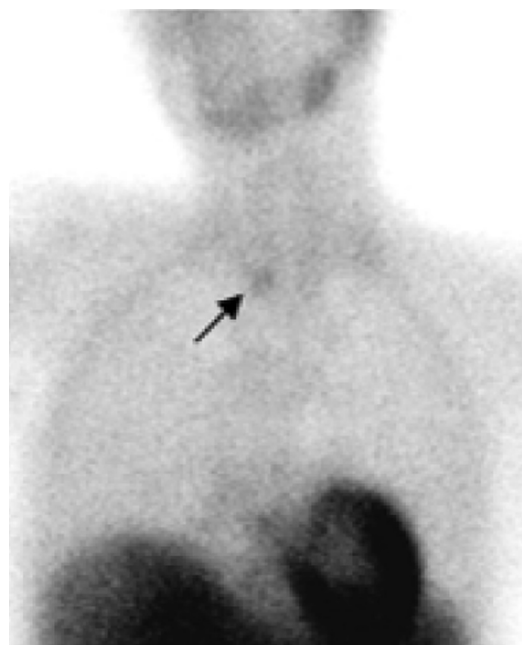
Single-photon emission computed tomography. A strong signal (arrow) is noted at the right inferior thyroid bed.
